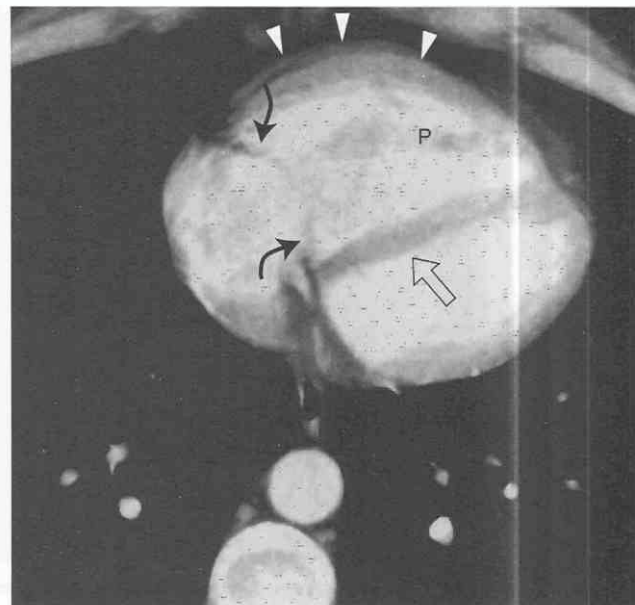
Right ventricular hypertrophy in a patient with pulmonary arterial hypertension secondary to chronic obstructive pulmonary disease. Axial contrast-enhanced CT image shows marked thickening of the free wall of the right ventricle (arrowheads), which is as thick as the interventricular septum (open arrow). P, right ventricular papillary muscle. Curved arrows point to the tricuspid valve.
